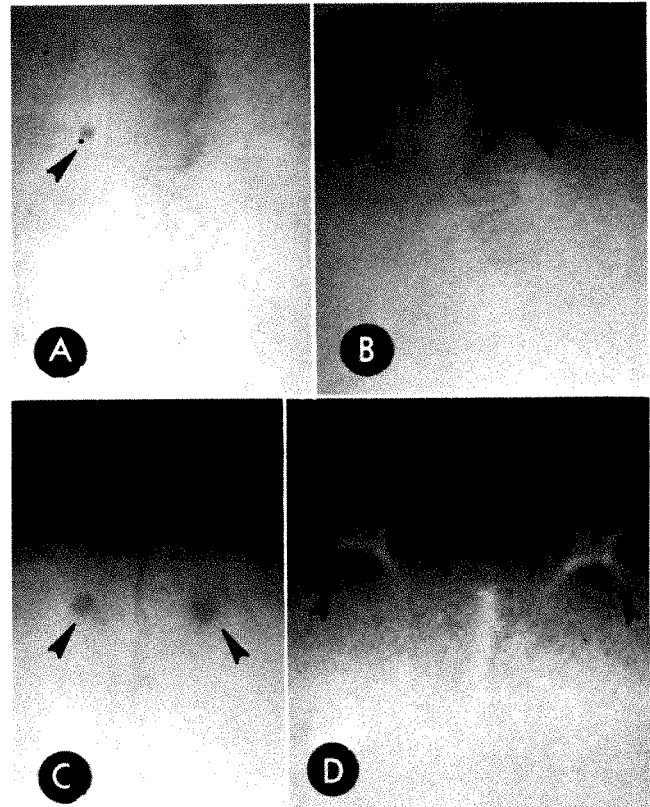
Frontal skull roentgenograms of four children aged 2, 5, 2, and 13 years respectively, with small parietal foramina (arrows). *A* and *B*, Unilateral; *C*, bilateral; *D*, bilateral parietal foramina causing starlike densities. Foramina appeared patent in lateral projection.
